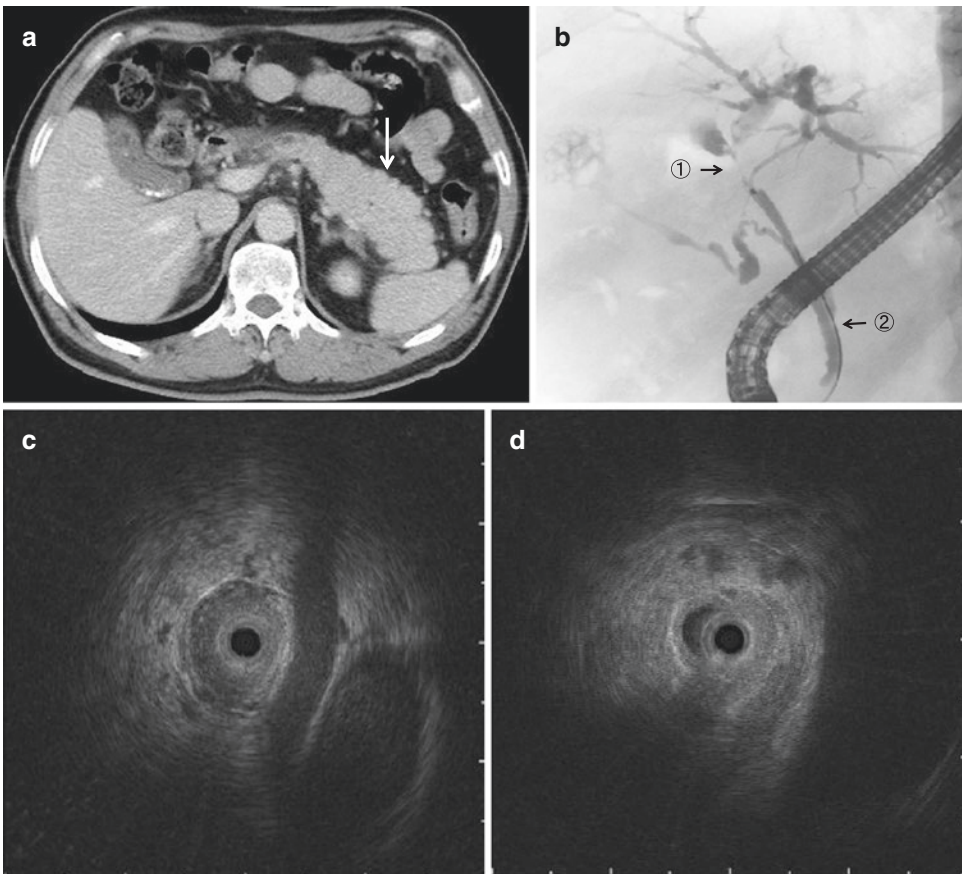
IgG4-related sclerosing cholangitis with a stricture in a bile duct in the hepatic portal region (case 2, pretreatment). (a) Abdominal computed tomography image showing swelling in the pancreatic tail (arrow). (b) Endoscopic retrograde cholangiopancreatography image
